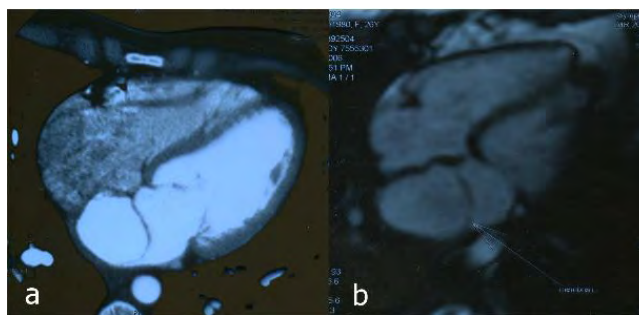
View of the membrane with Magnetic Resonance Imaging (A) and Computed Tomography Angiography (B).
